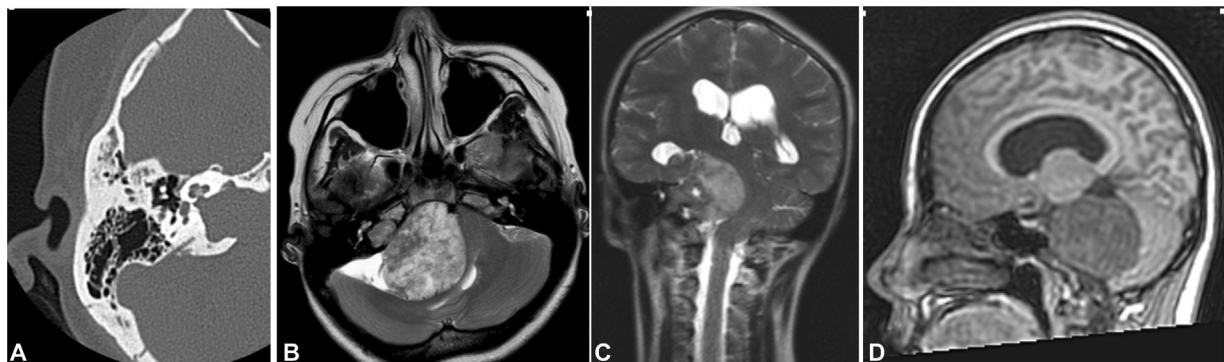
Preoperative imaging of patient 21 with a large vestibular schwannoma and a contracted mastoid process. (A) Axial CT scan of the right mastoid. (B) Axial T2 MRI. (C) Coronal T2 MRI. (D) Sagittal T1 MRI, no contrast. CT, computed tomography; MRI, magnetic resonance imaging.
